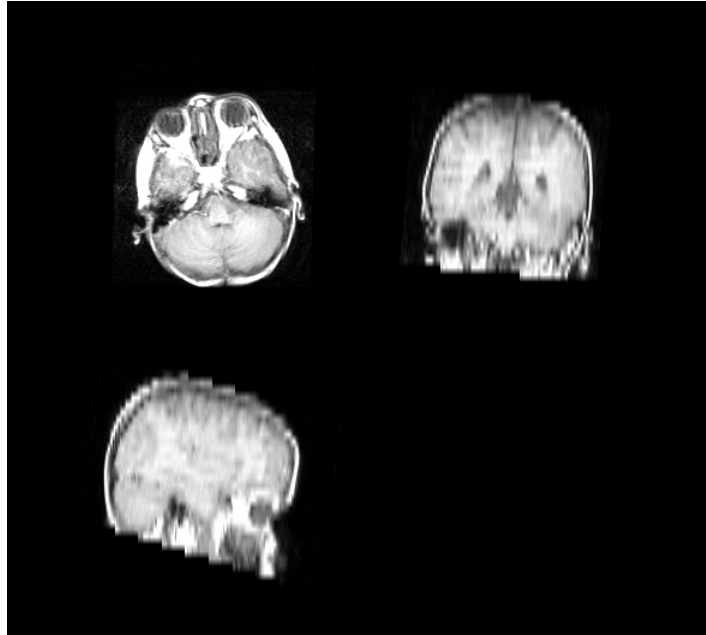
T1-weighted MPR Magnetic Resonance Image of a 4-years old patient after the radiation treatment, in transverse, coronal and sagittal view.
